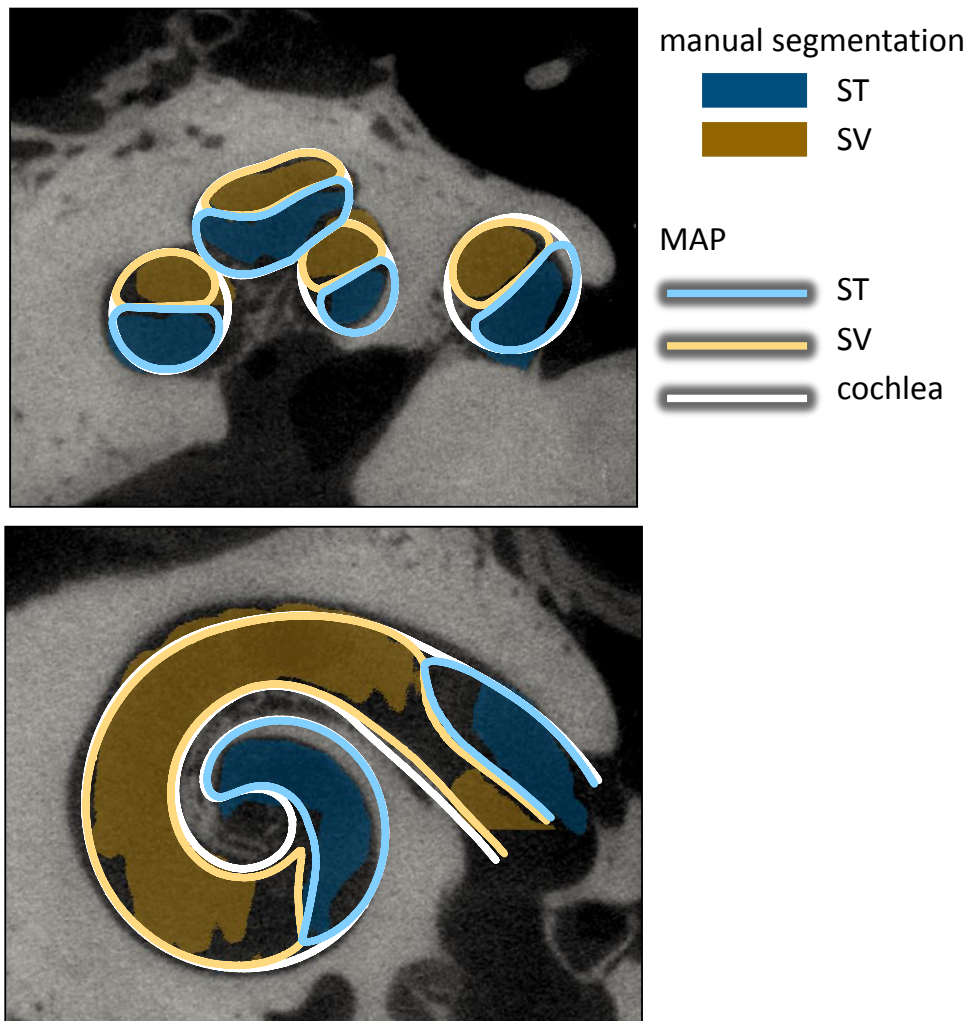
Shape models of the cochlea (light line) of the MAP of patient 1 with the segmented ST (blue) and SV (orange) on μ CT images.
